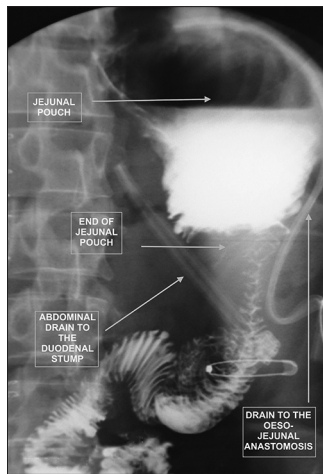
Water-soluble contrast swallow X-ray at POD 6
